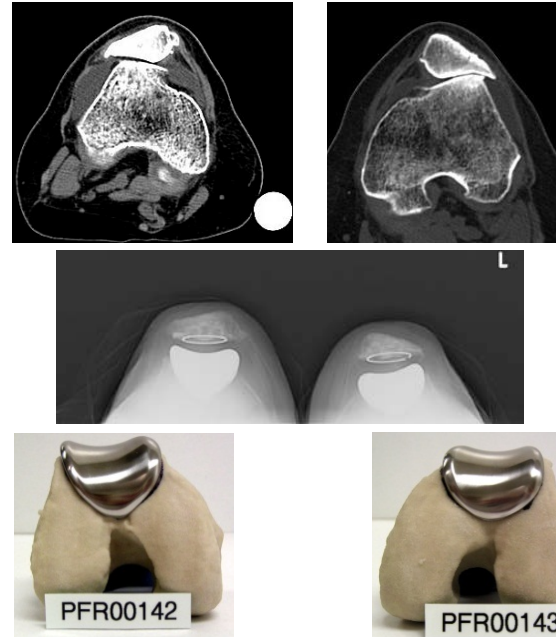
A 56 year old female with bilateral isolated end-stage patellofemoral arthritis, with bilateral trochlear dysplasia (top row), treated with patient-specific patellofemoral prostheses. Post-operative Merchant views (middle row) demonstrate proper orientation of patellofemoral implant components. Placement, fit, and alignment of both patient-specific trochlear implants were confirmed by the manufacturer using the patient-specific CT bone models prior to final polishing (bottom row).
